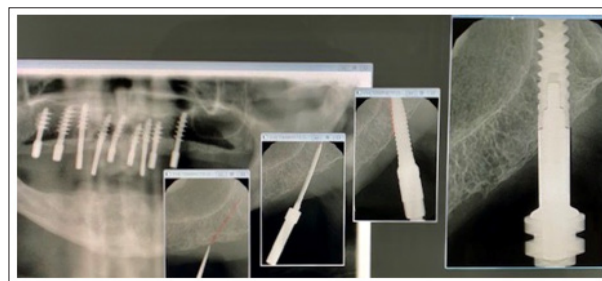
X-ray Monitoring of Implant Insertion in the Tuber Area
